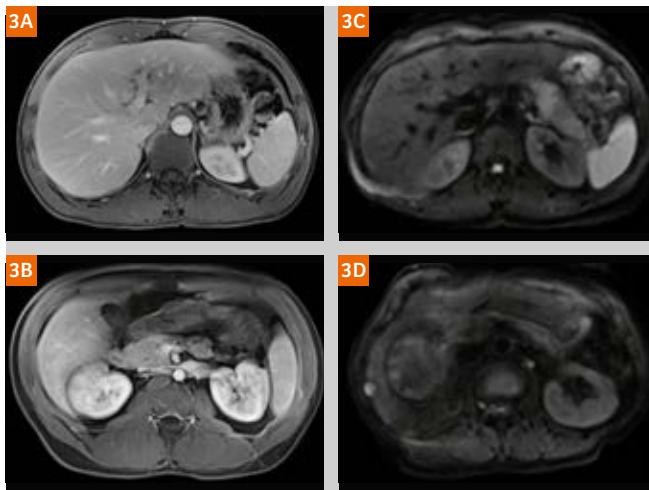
T1-weighted post-contrast 3D spoiled gradient-echo 2-point Dixon sequences with excellent image quality (3A) and with mild respiratory motion artifacts (3B). Single-shot diffusion-weighted echo-planar imaging sequence with slice-specific shim optimization with excellent image quality (3C) and with mild motion artifacts (3D).
